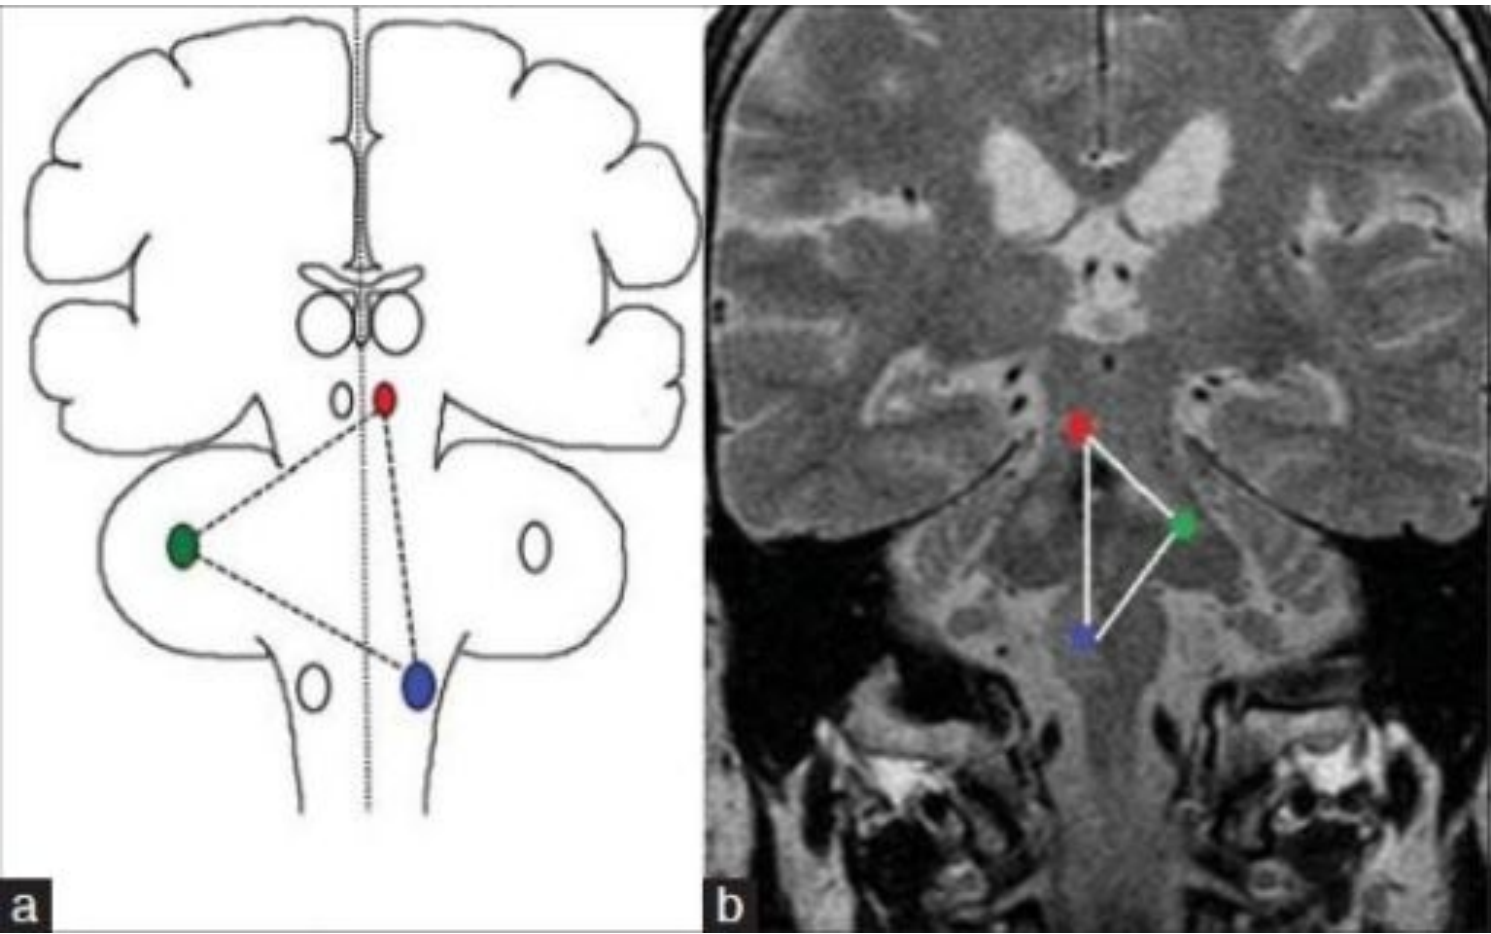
This image showcases the Triangle of Guillain Mollaret in both sketch and MRI Imaging. The Inferior Olivary Nucleus is shown in blue, the Dentate nucleus in green, and the Red Nucleus in red.
